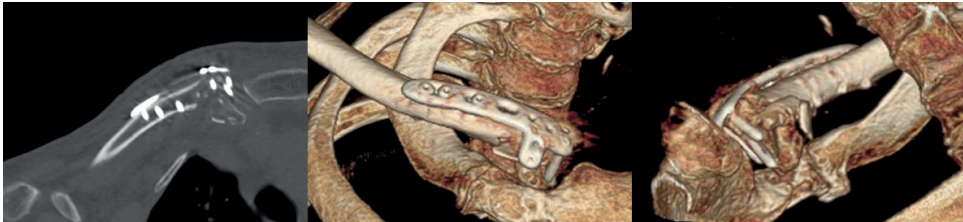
Post-operative CT with implant failure. Plate positioning was too medially with screws being intra-articular
